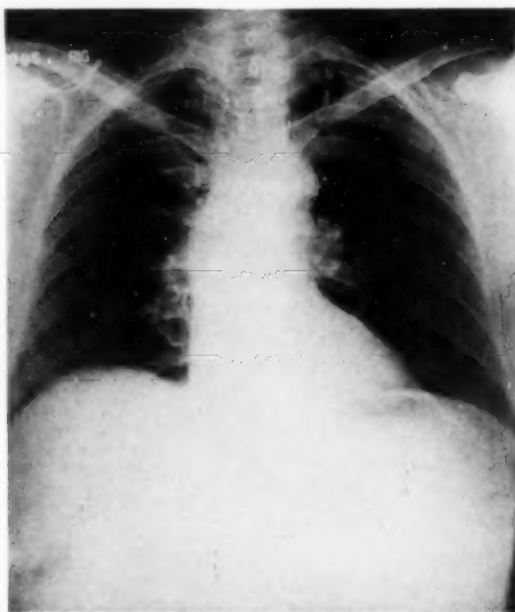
Roentgenogram of the same patient as in Figures 1 and 2, made 34 years later and interpreted by radiologist, L. C. Wurster, as showing nothing of pathologic significance. (Patient 70 years old).
